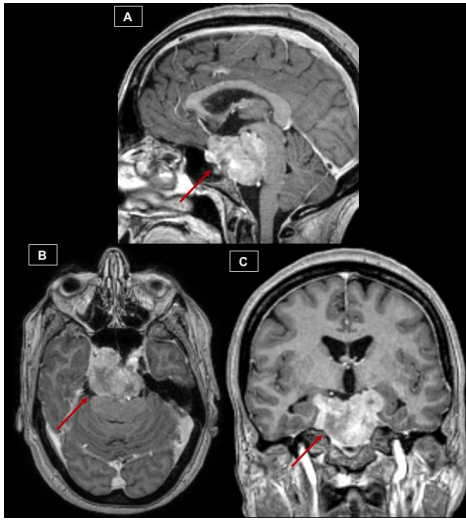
Sagittal (A), axial (B), coronal (C) T1-weighted post-contrast MR images showing a chordoma (red arrows) with intense contrast enhancement.
